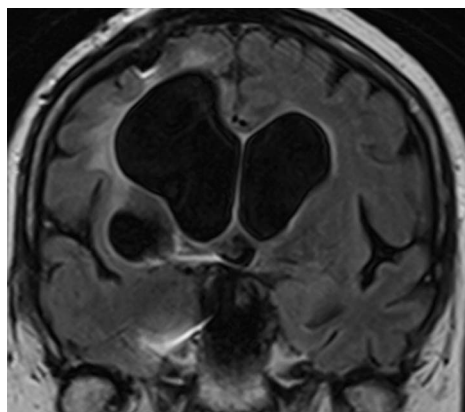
Magnetic resonance image taken 5 months after the second craniotomy.
